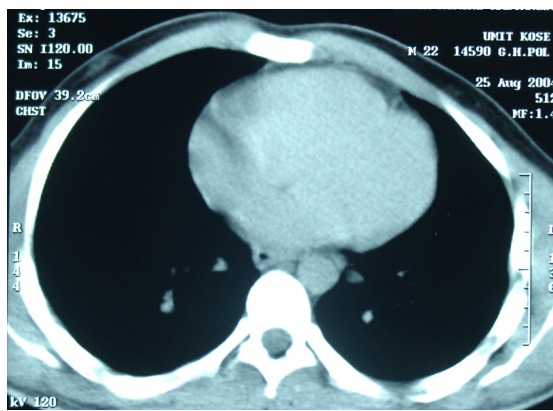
CT Scan after 7 months treatment
